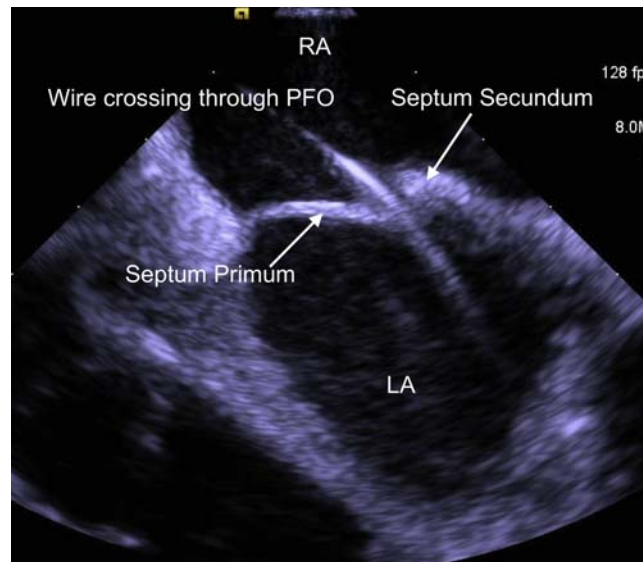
Intracardiac echocardiography image showing the guidewire crossing from the inferior vena cava through the patent foramen ovale (PFO) and into the left atrium (LA). RA, right atrium.
